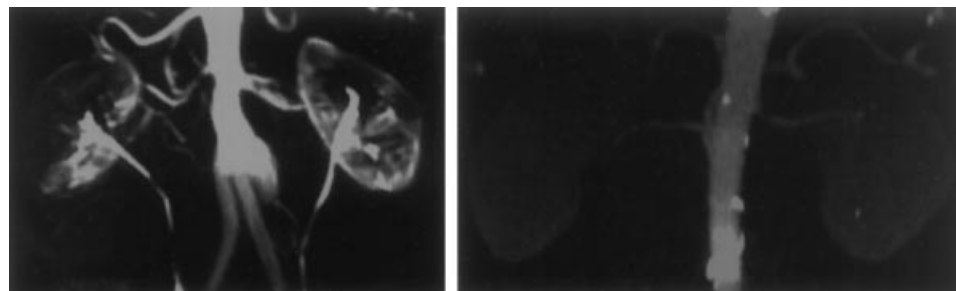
Fast MRI with contrast material (left—courtesy of GE Medical Systems) reveals major vessels as well as kidney function through visualization of the ureter because the contrast material is excreted into the ureters by the kidney. X-ray CT (right—courtesy of Siemens Medical Systems) using contrast material shows vessels and the presence of severe atherosclerosis revealed by multiple large calcium deposits in the aorta.
